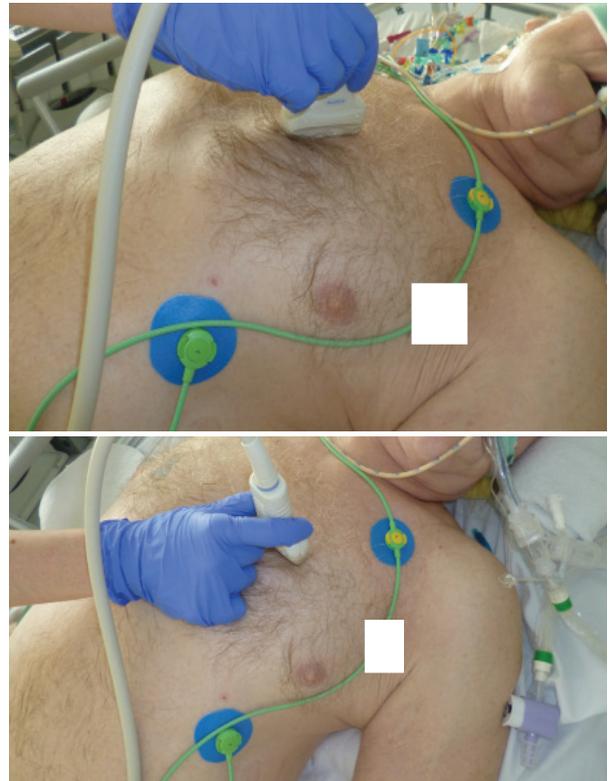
Thoracic sonography (first image: cross section to rib, second image: longitudinal section to rib): The linear transducer is placed at the highest point of the thorax. This is the sternum in case of a lying patient. For the question of a left-sided pneumothorax, the transducer is placed parasternally left, for the question of a right-sided pneumothorax, the transducer is placed parasternally right.
